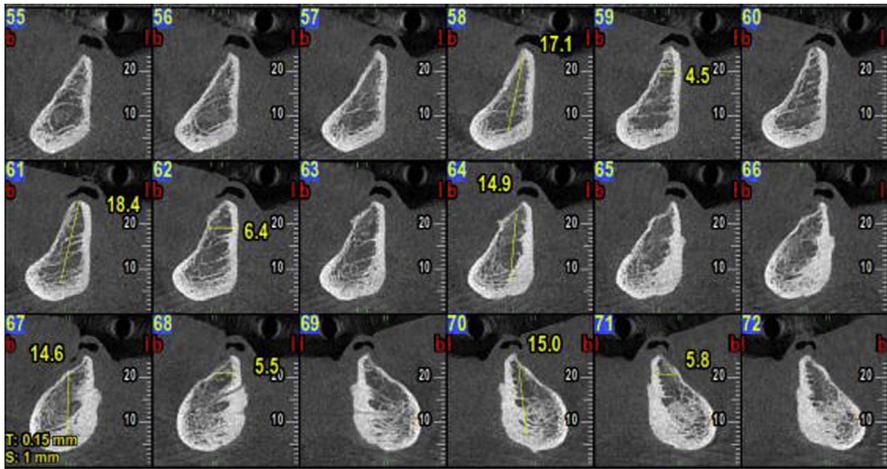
Cross-sectional images from the CBCT on a fully edentulous mandible.
